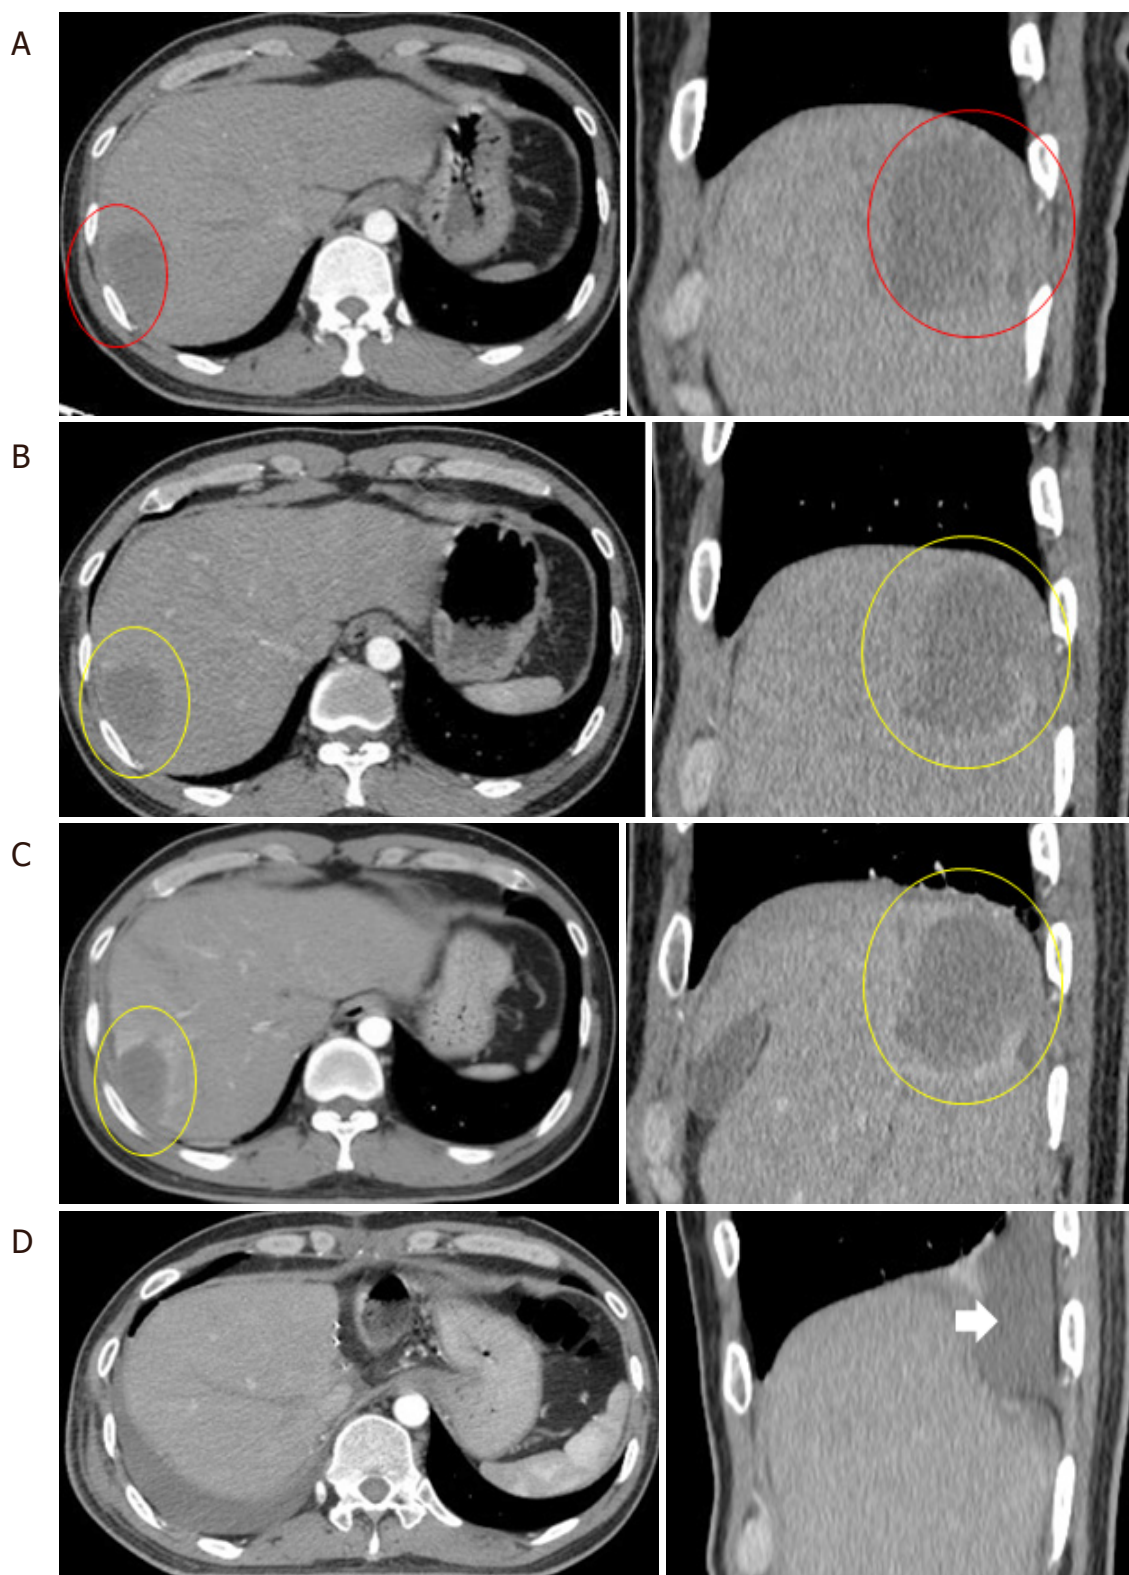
The patient's CT images. A: non-contrast enhancing primary tumor (red rings) in arterial phase CT images pre SBRT; B, C: mild contrast-enhancing of normal liver tissue surrounding the primary tumor (yellow rings) in arterial phase CT images one month and three months post-SBRT; D: new transplanted liver and local pleural effusion in the right lung (white arrow). With courtesy of Department of Radiation Oncology and Radiosurgery and Department of Hepatobiliary and Pancreatic Surgery, Military Central Hospital 108. SBRT: stereotactic body radiation therapy
